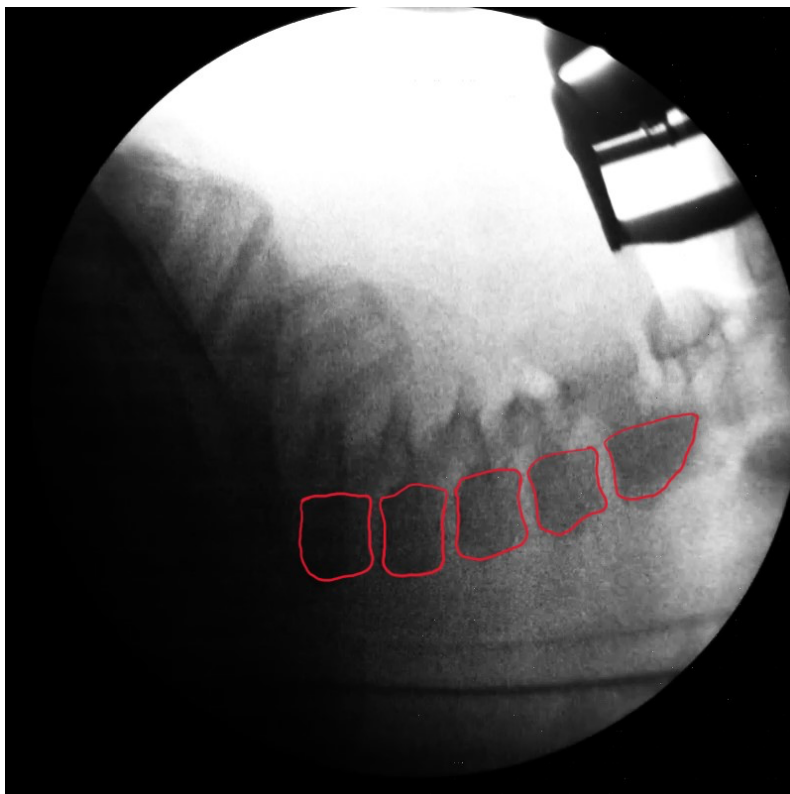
An annotated frame of the X-ray movie from test #1.
